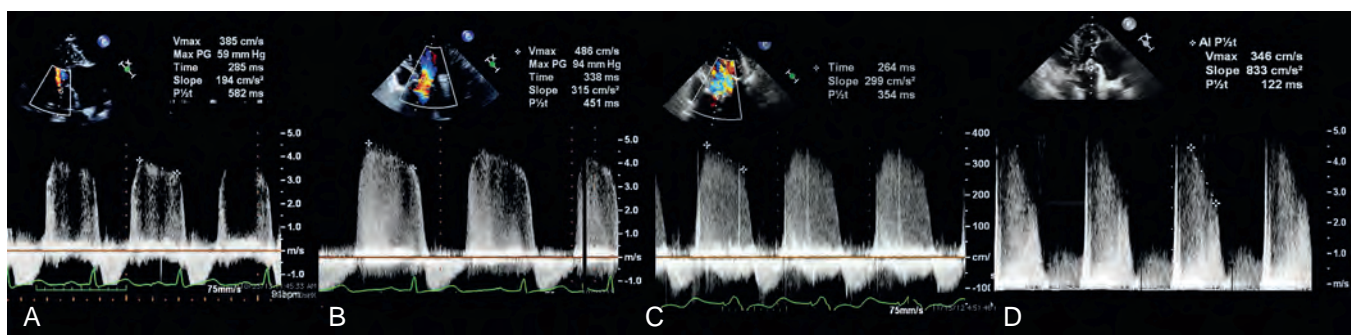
Pressure half time (PHT): aortic insufficiency (AI). (A–D) From left to right the Doppler profiles show reduction in PHTs from 582 ms to 122 ms, which is consistent with increasing severity of AI. The limitation of the PHT assessment is the impact on net compliance, which in turn is affected by a host of variables including acuity of AI, coexistence of aortic valve stenosis, and a history of hypertension. Although supportive of different degrees of AI, the PHT assessment should not be used as the sole determinant of AI severity. Qualitatively, the Doppler profile in (A) is not as dense or complete as the others, reflecting the regurgitant volume. The more cells that pass through, the more dense the flow profile will be.
